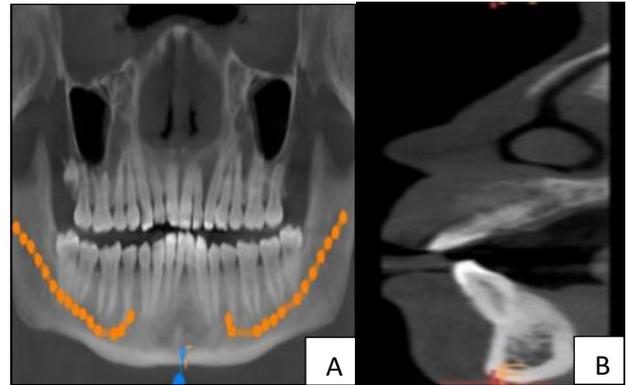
(A and B): Panoramic view of CBCT scan showing interradicular radiolucency and divergence of roots of #22 and #23 and paraxial view showing unilocular radiolucency.
